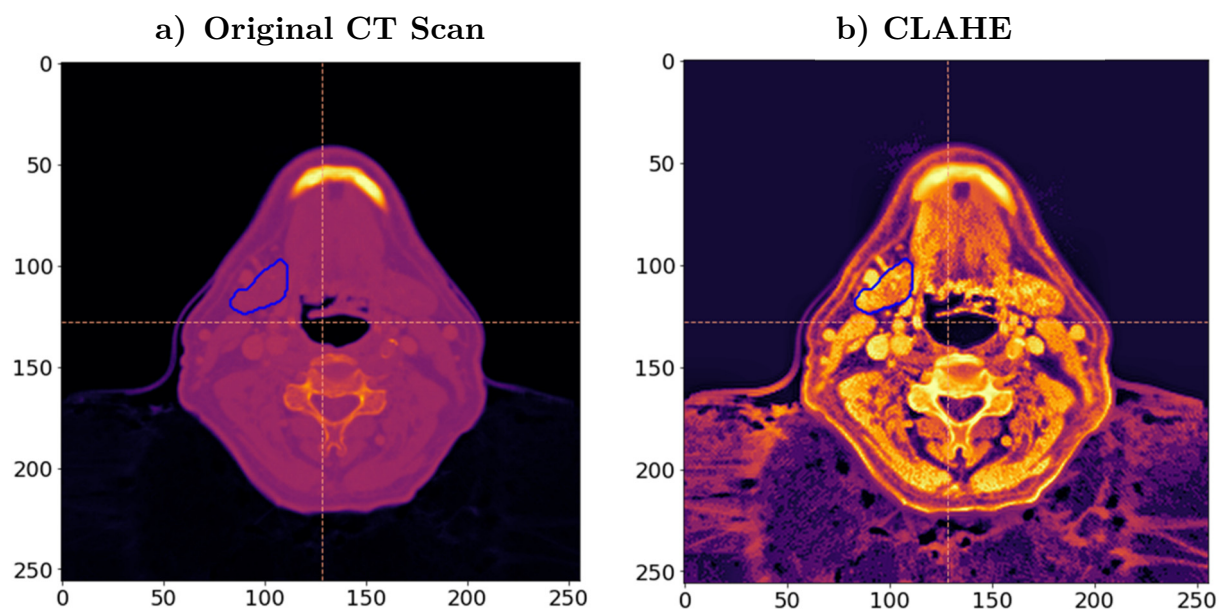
2. a) Original CT scan with the contour of an example structure (right submandibular gland); b) The same CT scan after pre-processing with a contrast-limited, adaptive histogram equalization algorithm (CLAHE).
